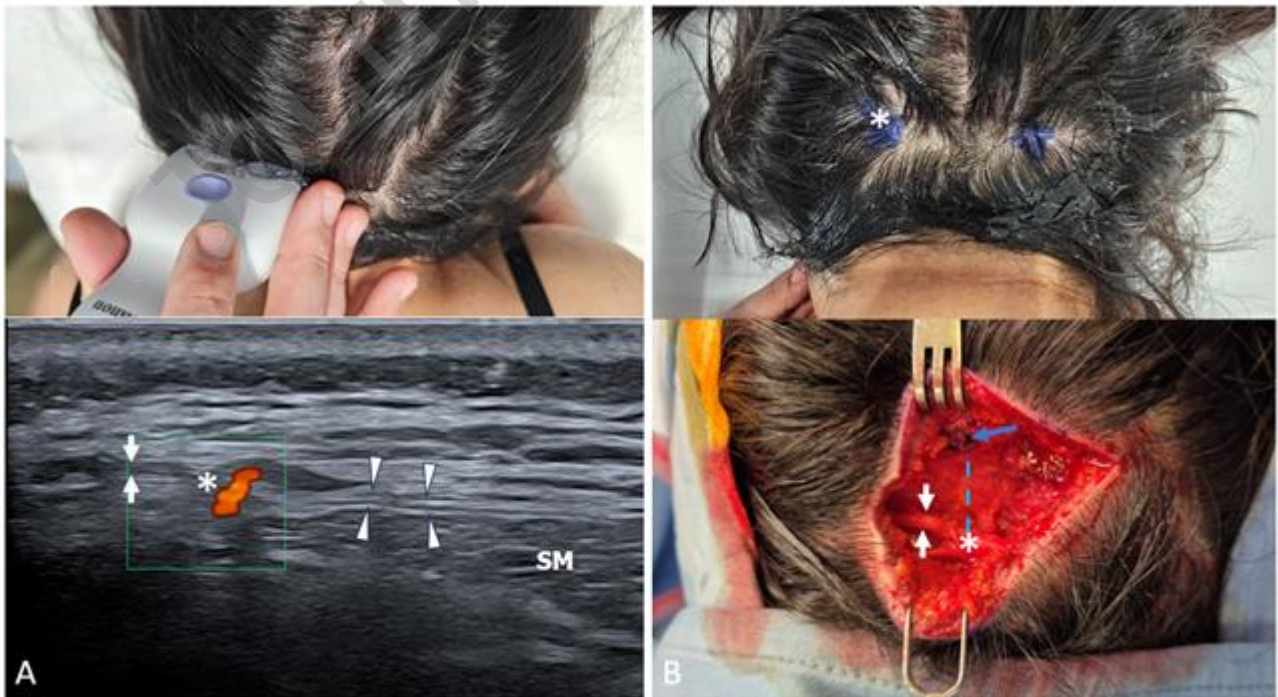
A: Ultrasound longitudinal view of the left GON (white arrowheads and arrows) located between the trapezius aponeurosis and the semispinalis muscle (SM). The segment of the GON, proximally to its crossing with the left occipital artery (red Doppler signal) and the trapezius fascia, appears normal (white arrowheads). However, distal to the crossing point (white asterisk), the nerve appears enlarged (white arrows). Additionally, at the crossing point, the occipital artery is ectatic, with a hypoechoic halo surrounding it. However distal to the crossing point (asterisk), the nerve appears enlarged (white arrows). Also, at the crossing point, the artery appears ectatic with hypoechoic halo surrounding it. B: The enlarged GON (white arrows) crosses (asterisk) the occipital artery (blue dotted line), which appears barely coagulated (blue arrow) in the image.
